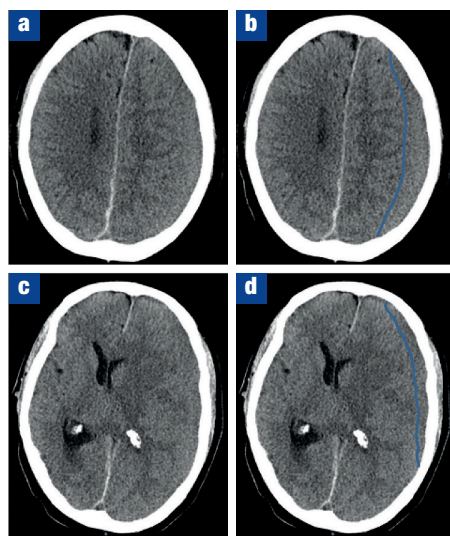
a. and c. Selected axial slices of an unenhanced computed tomography scan. b. and d. The same axial slices with the isodense subdural collections outlined. Note the midline shift and that the grey-white matter interface does not extend all the way to the skull vault. These are key features to look for when identifying an isodense subdural haemorrhage.
